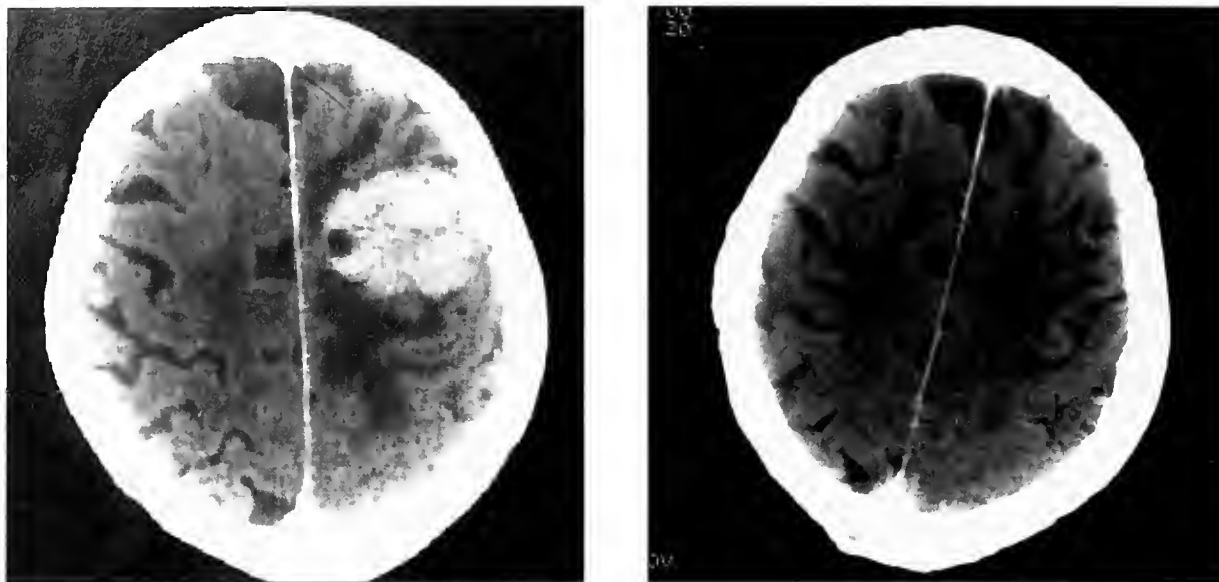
Left—Preoperative CT scan of 3.2 cm recurrent small cell carcinoma metastatic to the left parietal lobe in a patient with a progressive right hemiparesis. Right—Follow-up scan 3 months after radiosurgery (18 Gy dose to 80% isodose line), shows dramatic decrease in lesion size. The patient's hemiparesis resolved, with return of function.
